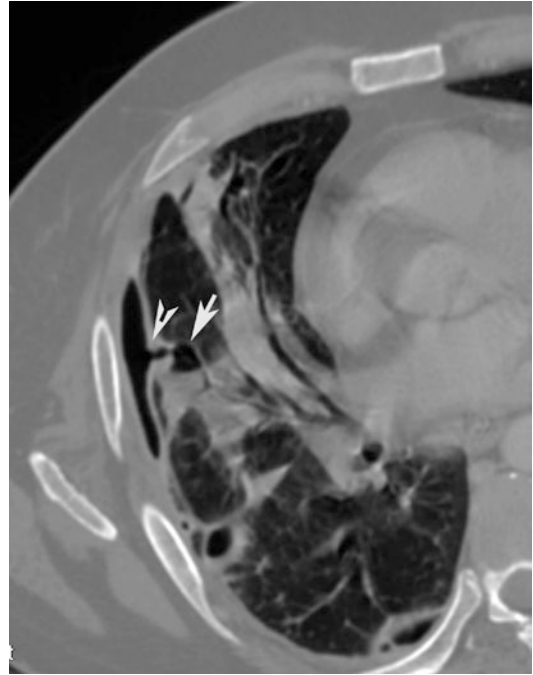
Post-contrast CT axial scan demonstrates a small air-containing pulmonary cavity with fluid level (*arrow*) ruptured into the pleural space (*arrow tip*) with a small left pneumothorax
